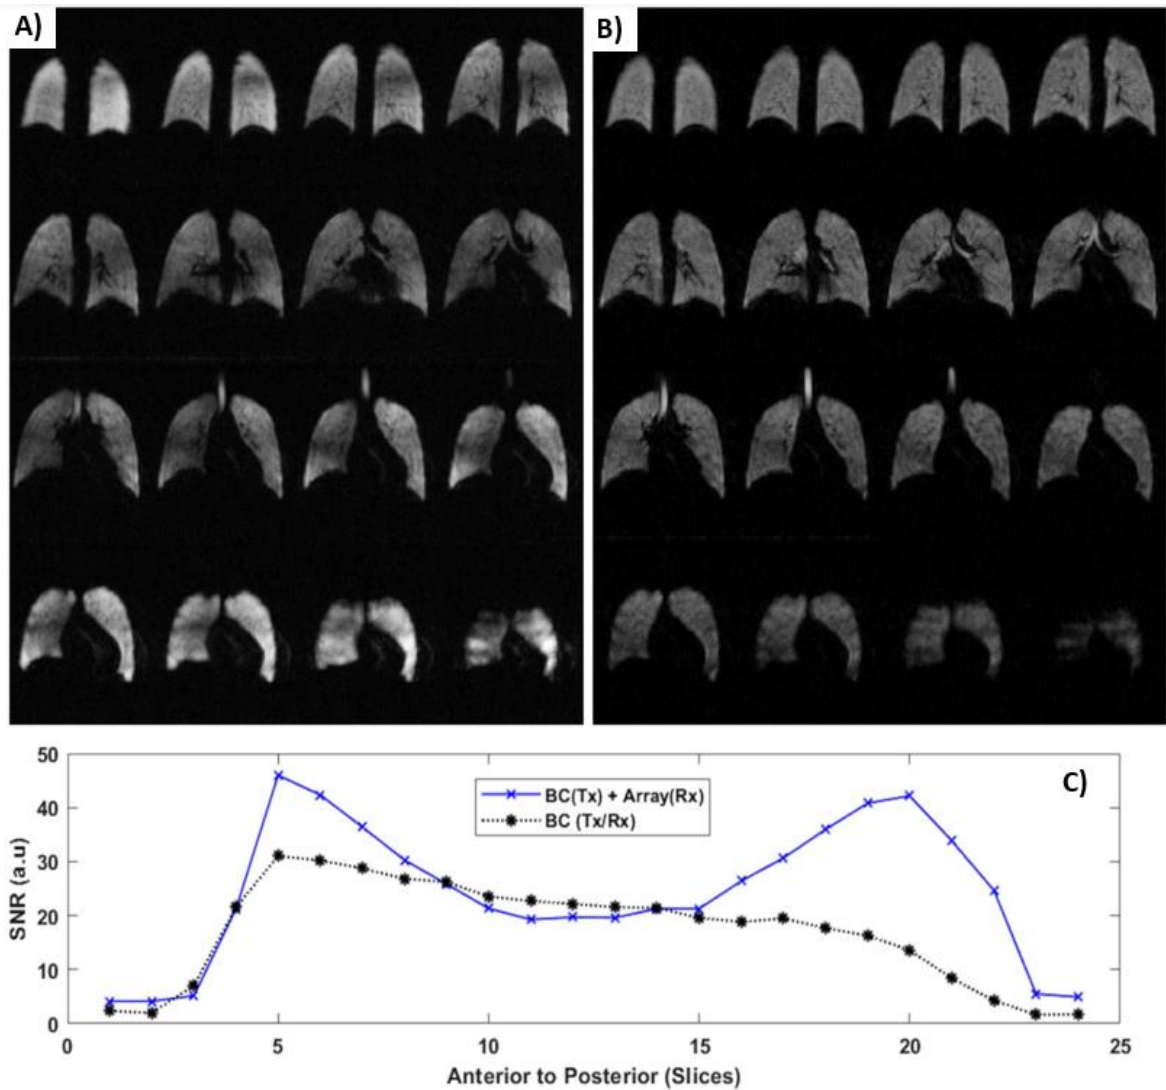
a) Ventilation lung imaging with Hyperpolarised ^{129}Xe MRI with the birdcage and coil array; b) ventilation imaging with birdcage as a transceiver coil, c) comparison of means SNR values calculated for each slice between the two images setup. Reproduced from [172] under creative commons license.
